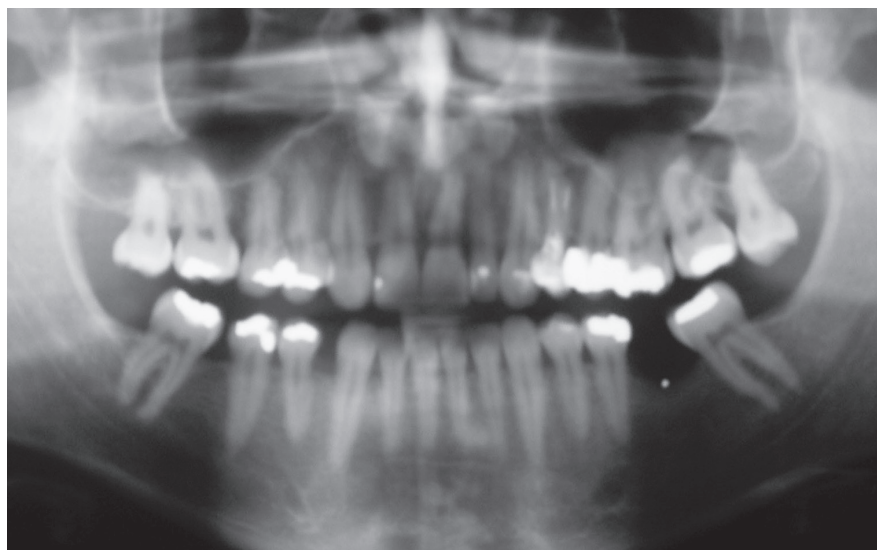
Panoramic radiograph. Observe the absence of teeth #12, 16, 36, 38, 46 and 48.
